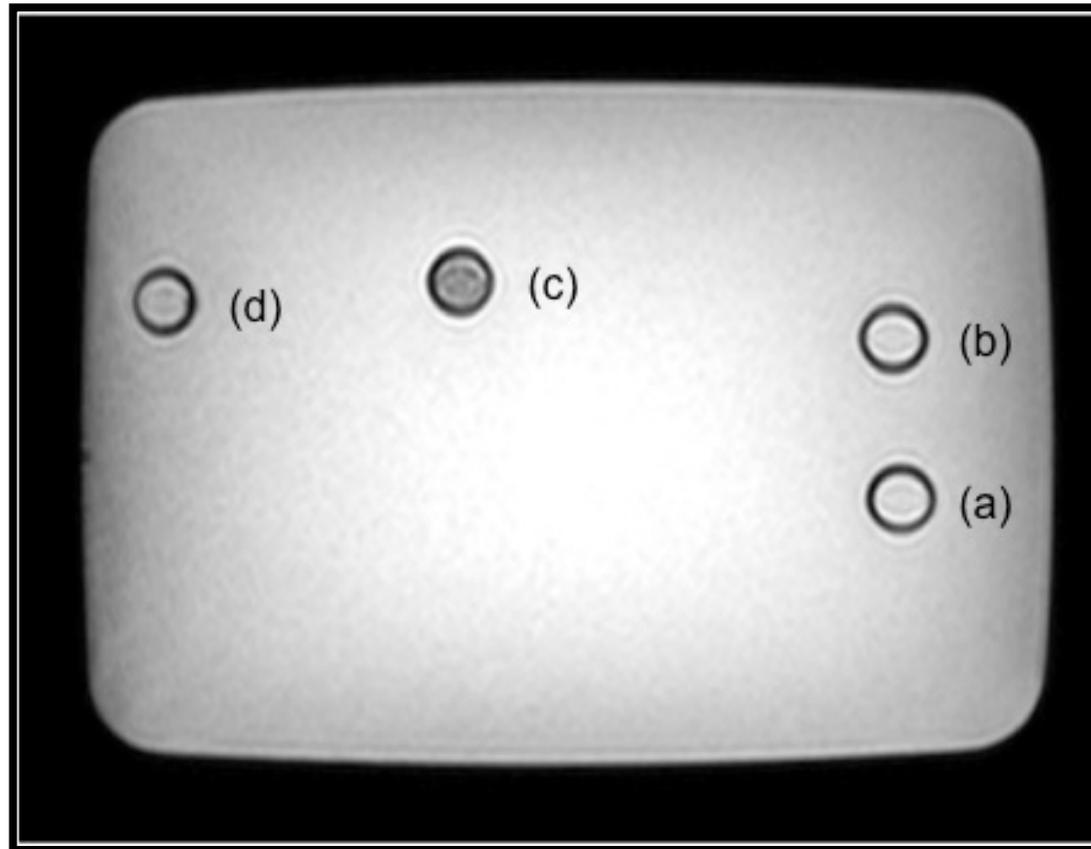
Gradient echo MRI of labelled CD34+ cells.
